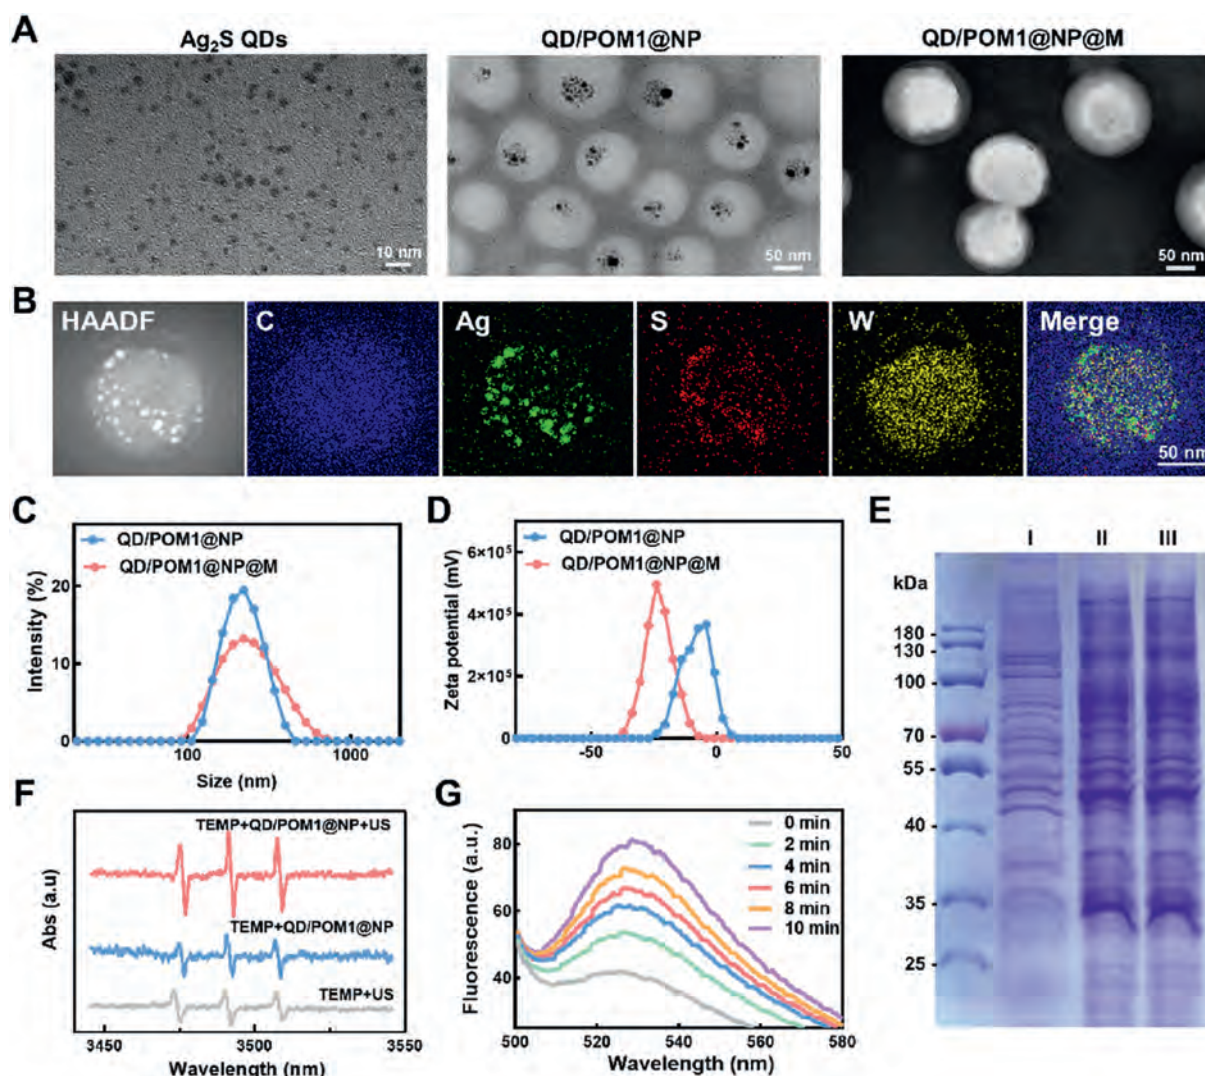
Characterization of QD/POM1@NP@M. (A) TEM images of Ag₂S QDs, QD/POM1@NP, and QD/POM1@NP@M, scale bar = 10 or 50 nm. (B) Element mapping images of QD/POM1@NPs, scale bar = 50 nm. (C) Size distribution of QD/POM1@NP, and QD/POM1@NP@M measured by DLS. (D) Zeta potential of QD/POM1@NP, and QD/POM1@NP@M measured by DLS. (E) SDS-PAGE image. I: cell lysate, II: cancer cell membrane, III: QD/POM1@NP@M. (F) ¹O₂ produced by QD/POM1@NP@M under different treatments was detected by ESR (Ultrasonic parameter: 1.5 W/cm², 3 min) (G) ¹O₂ produced by QD/POM1@NP@M after different ultrasonic irradiation time was detected by SOSG (Ultrasonic parameter: 1.5 W/cm²).
